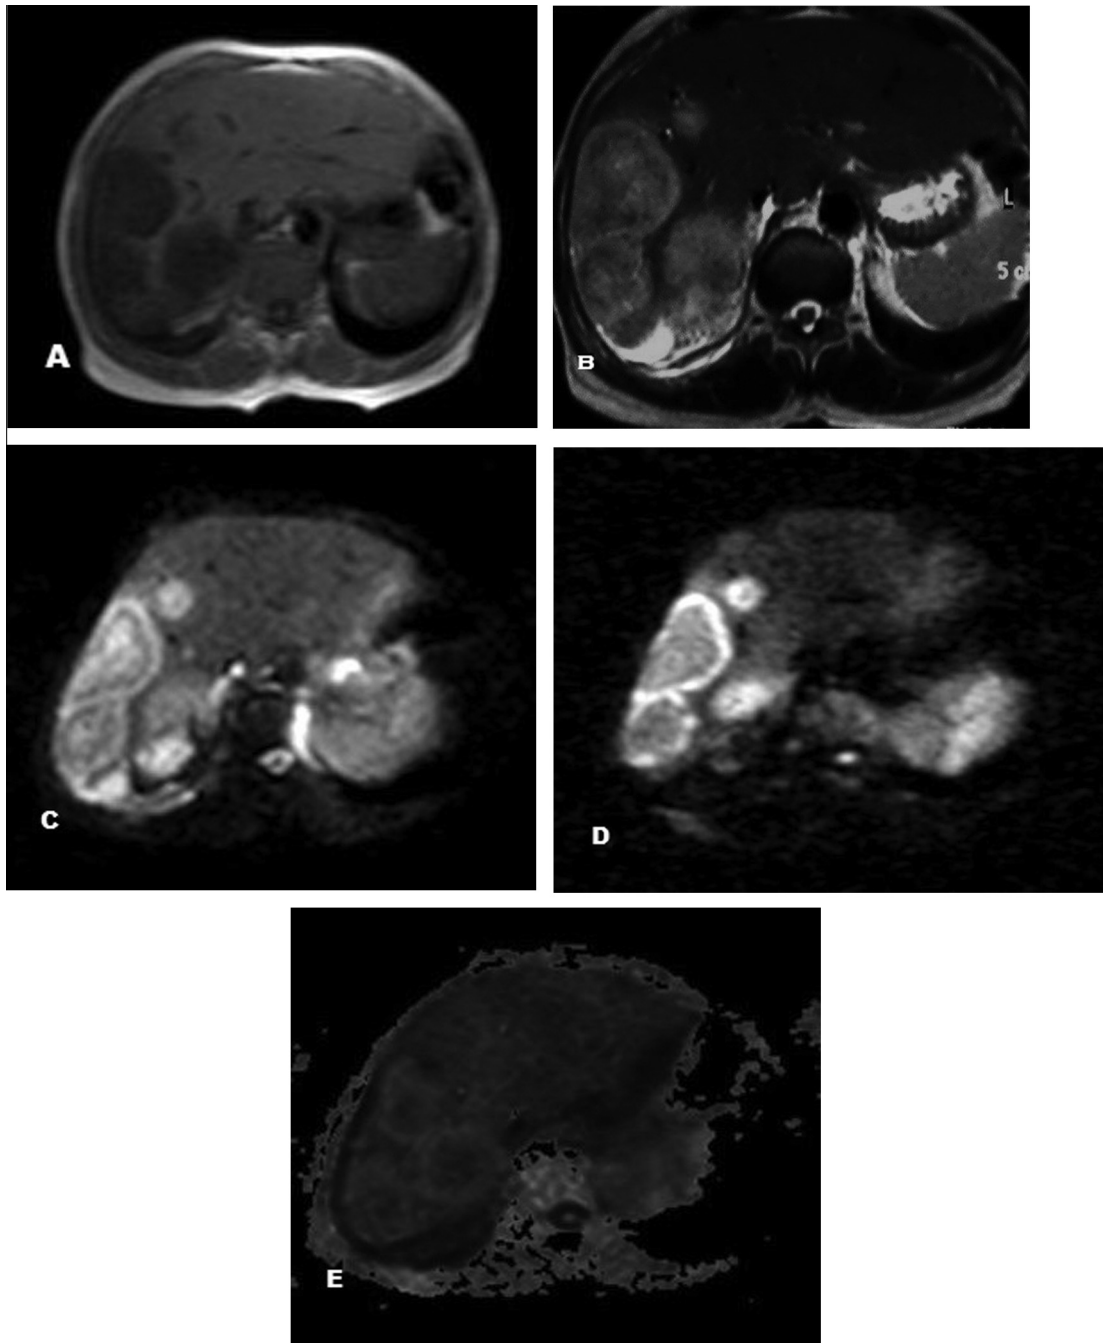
MR imaging of metastatic renal cell carcinoma in a 60 years old patient. (A) Axial T1GE reveals multiple hypointense focal lesions in the Rt lobe of the liver. (B) Axial T2 reveals multiple lesions of heterogenous hyperintensity. (C) Diffusion weighted echoplanar image with ($b = 0$) shows that the lesions show mixed intensity of isointensity and hyperintensity mainly hyperintensity. (D) Diffusion weighted echoplanar image with $b = 1000$ shows that the lesions show mixed hyperintensity. (E) ADC map of the lesion reveals hypointense signal. The lesion has low ADC value of $1.36 \times 10^{-3} \text{ mm}^2/\text{s}$ suggestive of malignant lesion.
